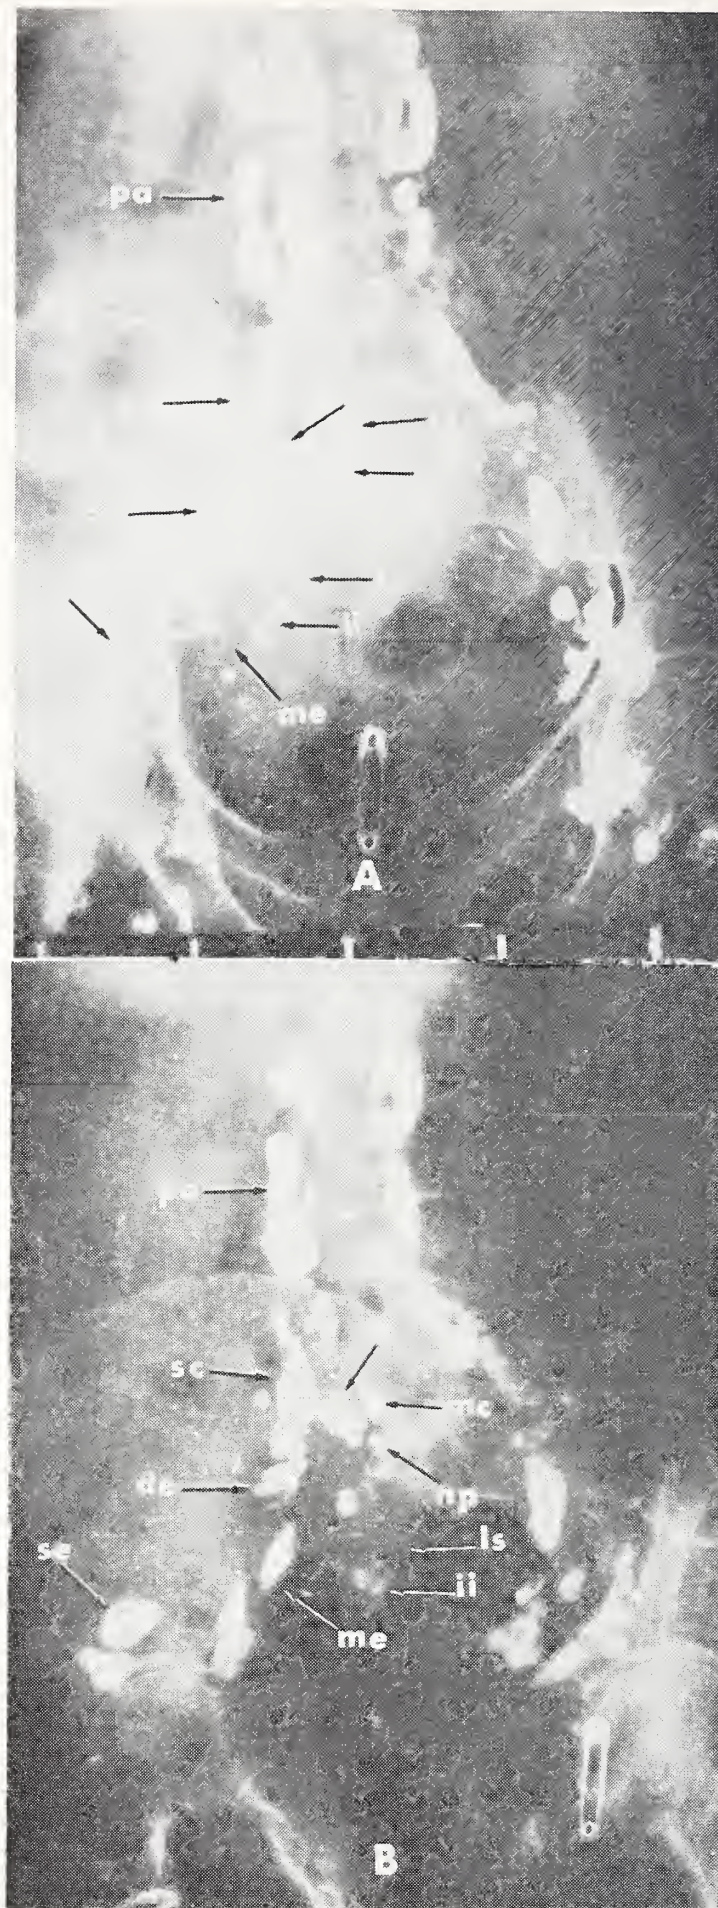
A) Anteroposterior roentgenogram (24 hour); B) right posterior oblique roentgenogram (24 hour); se) superficial lateral external iliac nodes; de) deep lateral external iliac nodes; me) medial external iliac nodes; ii) internal iliac nodes; ls) lateral sacral nodes; sc) superficial lateral common iliac nodes; dc) deep lateral common iliac nodes; mc) medial common iliac nodes; np) nodes of promontory; pa) para-aortic nodes.
